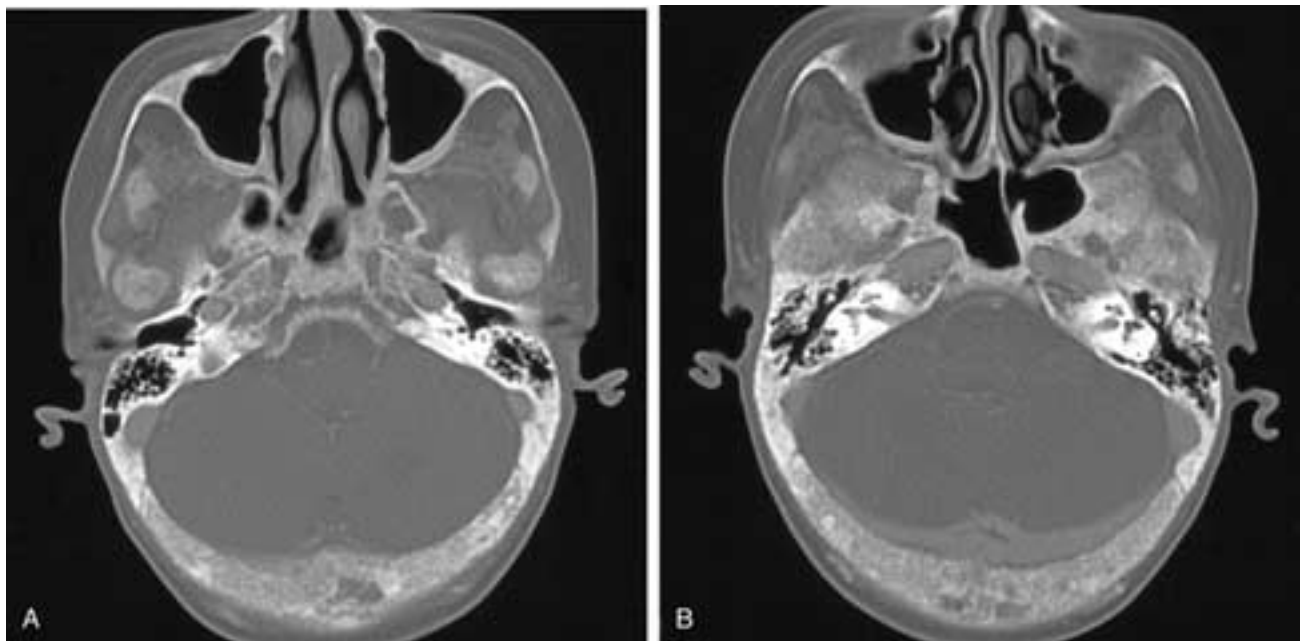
Hyperparathyroidism. A and B, Axial CT images show diffuse sclerotic change in the skull base. The cancellous trabeculae of the involved bones are blurred. Changes are also noted in the mandibular condyle and coronoid processes on each side.
